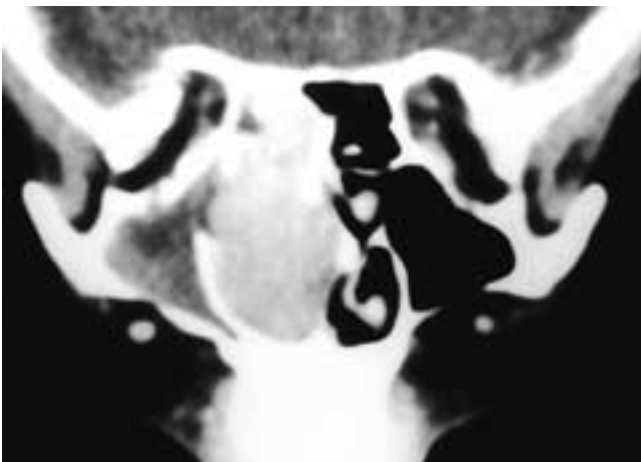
Coronal CT scan shows an enhancing right nasal fossa mass that extends into the right ethmoid sinuses. The right antrum is obstructed. There is primarily bone remodeling about the mass. This patient had a hemangiopericytoma.
